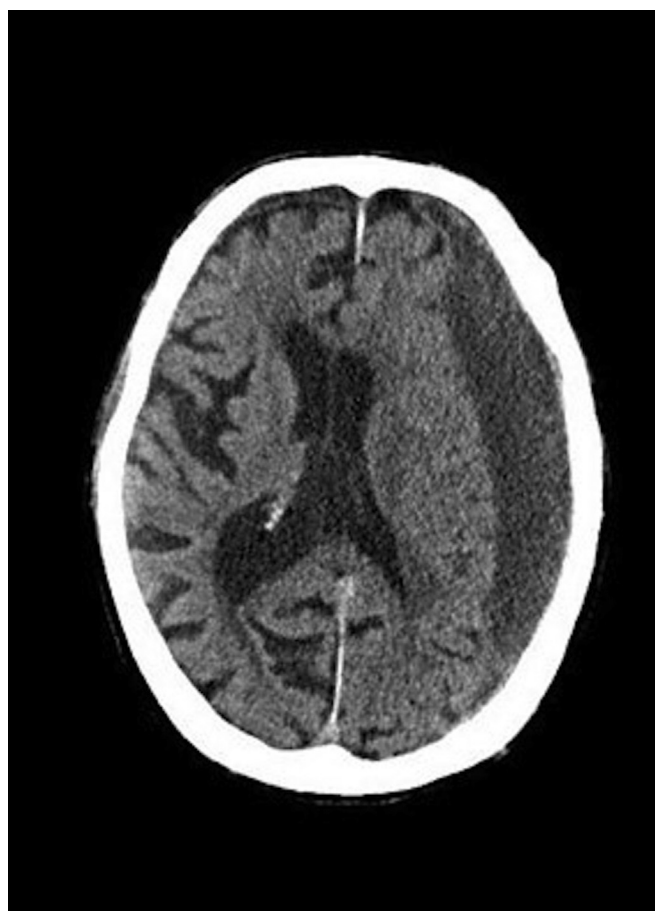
Axial noncontrast CT scan of the brain, left-sided subdural hematoma. Source: Reproduced from Radiopaedia.org, rID:71635, courtesy of Dr. Adam Eid Ramsey, under the Creative Commons Attribution BY-NC-SA 3.0.
